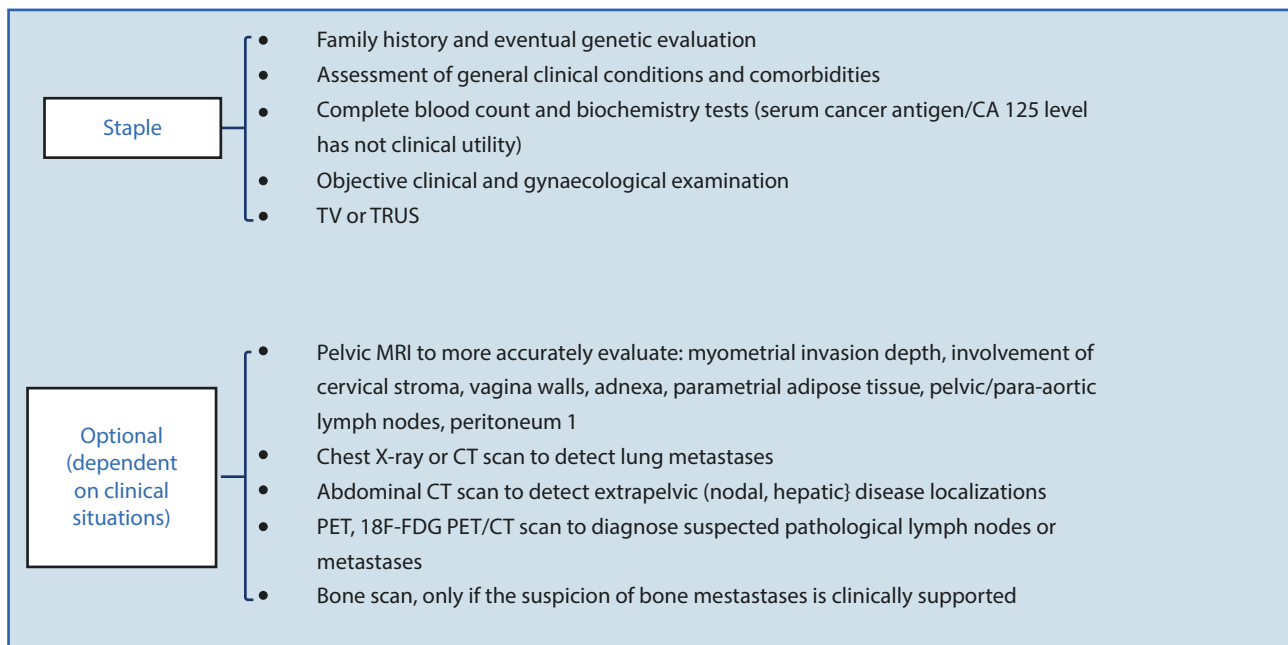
Pre-operative work-up. TRUS trans-rectal ultrasonography, MRI magnetic resonance imaging, CT computed tomography, PET positron emission tomography, FDG fluorodeoxyglucose
